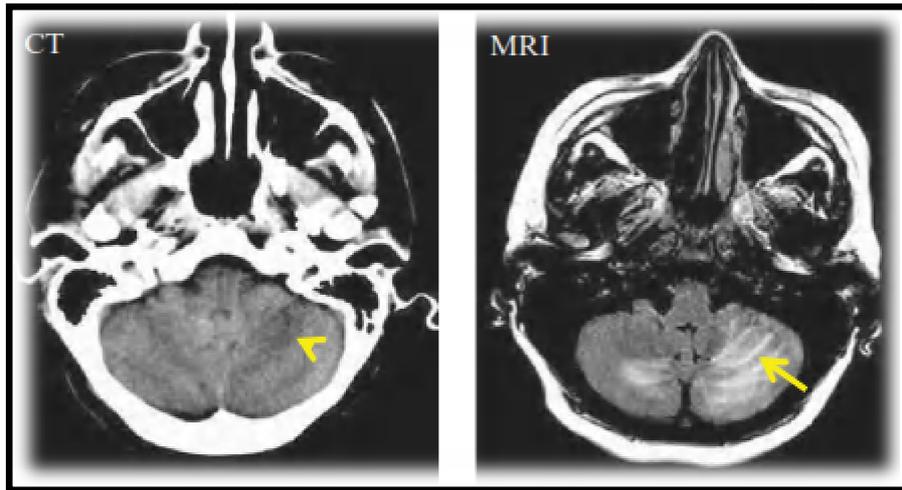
Two transverse slices of the same patient at the level of the posterior fossa, (a) Unenhanced CT axial reconstruction. (b) Unenhanced MRI FLAIR sequence axial reconstruction at the same level. [17]
